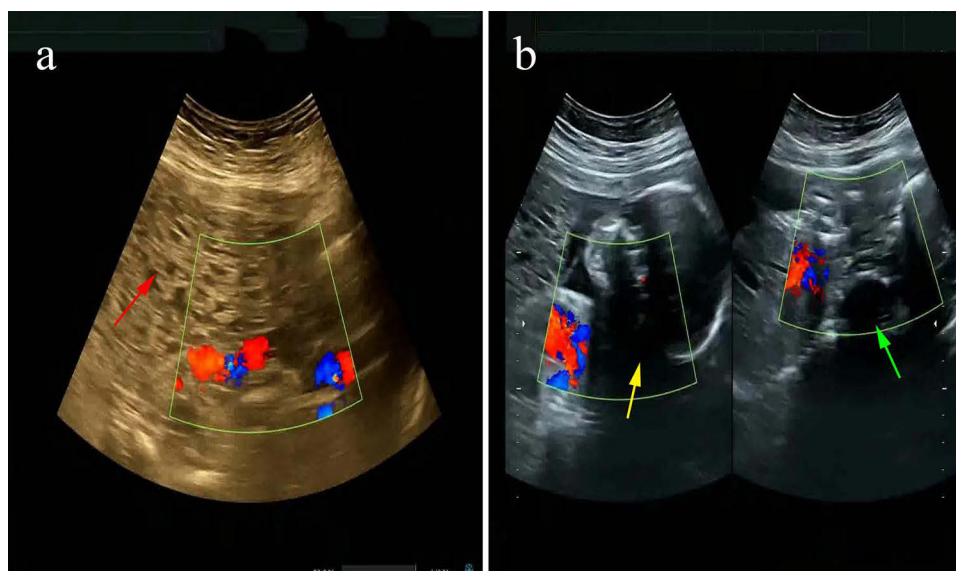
(a) Pelvic color Doppler ultrasound scan at 24 weeks revealed molar placenta of fetus B (red arrow). (b) Fetus A appeared to be developmentally appropriate for 23 weeks and 3 days gestation (yellow arrow), fetus B appeared smaller, consistent with 22 weeks and 6 days gestation (green arrow).
